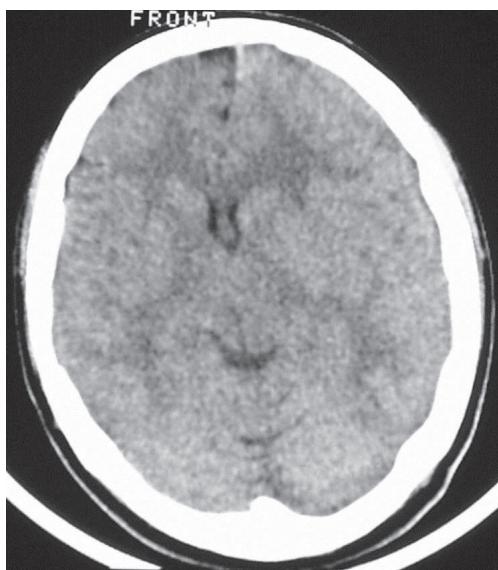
Brain CT Scan without intravenous contrast administration.
